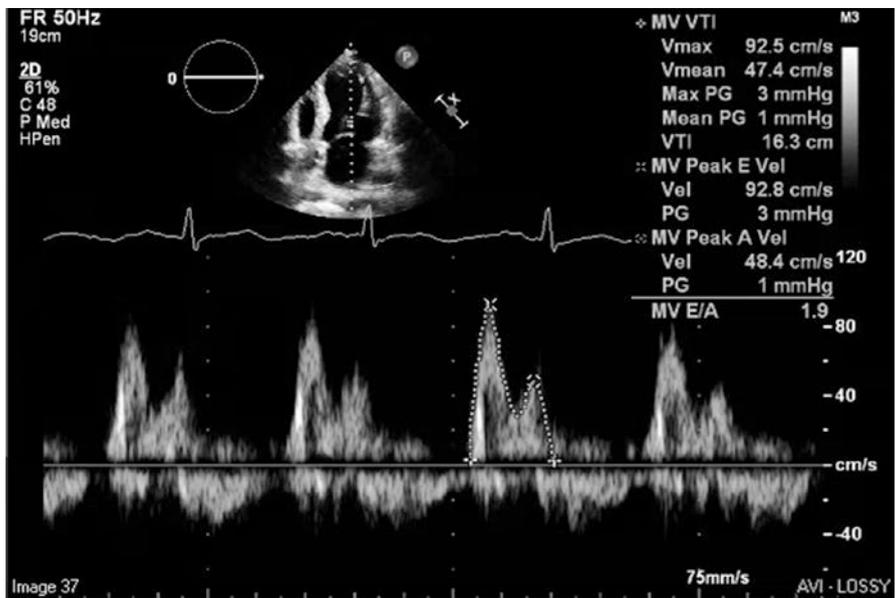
Pulsed wave Doppler sampled at the mitral valve
